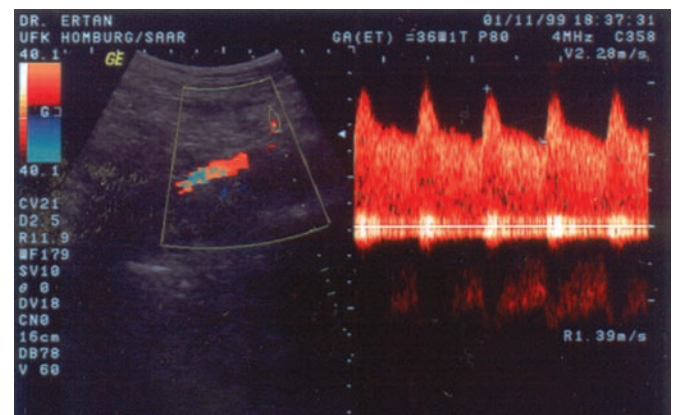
Flow in different parts of the uteroplacental circulation can be measured with color Doppler technology, here the relatively low resistance pattern of the uteroplacental arteries.
